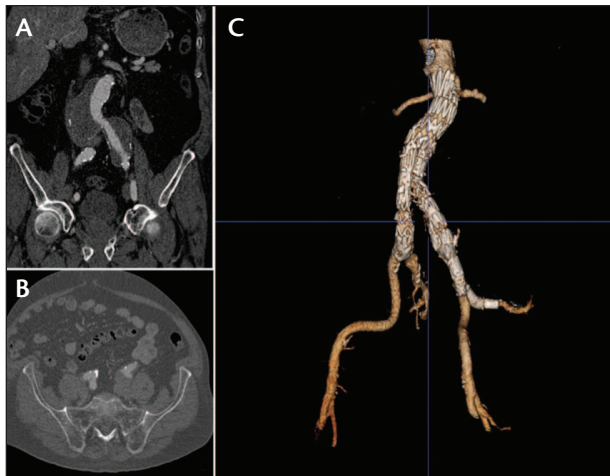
Use of an iliac side branch device to treat an aortoiliac aneurysm with a concomitant aneurysm of the left internal iliac artery (IIA). Preoperative CTA showing the aortoiliac aneurysm with involvement of the proximal IIA (A, B). Control CTA confirming successful treatment of the IIA aneurysm by combining a balloon-expandable and a self-expanding stent graft and relining them with a self-expanding nitinol stent up to the posterior trunk (C).
